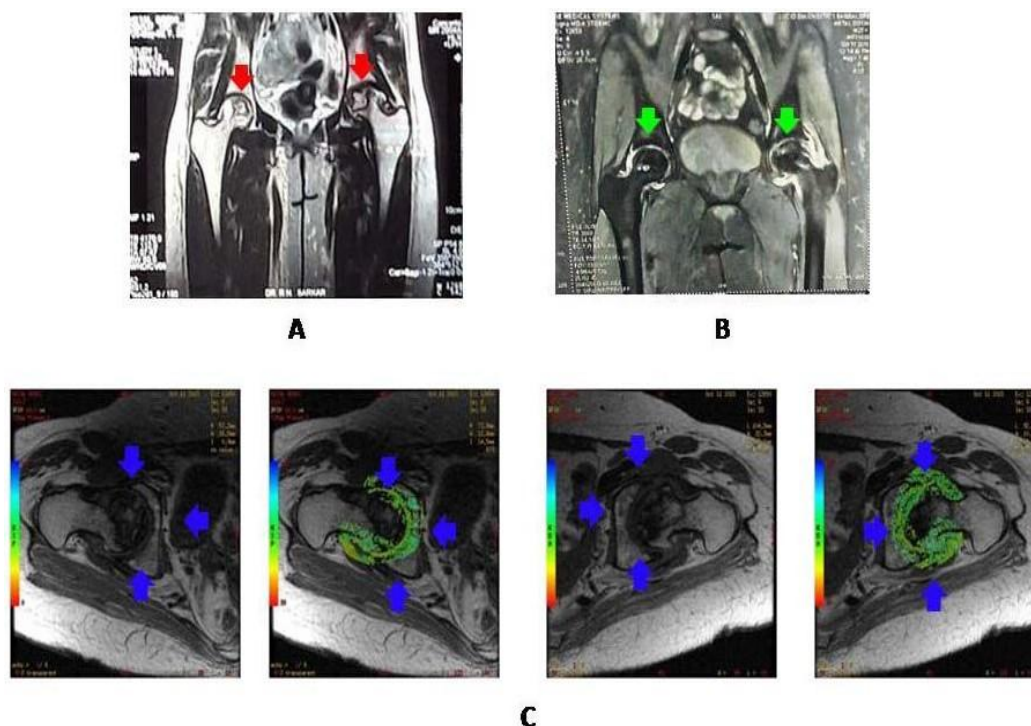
Pre and post treatment cartigrams showing improved cartilage thickness for patient case 1: A (Top Left) - Pre-therapy MRI; B (Top Right) - Post-therapy MRI; C (Bottom 4 images) - Post-therapy cartigrams consisting of alternating images of those with no colors for the lack depiction of hydration within the cartilage and those with colors of cartilage depiction of hydration. Red arrows indicate the location of loss of cartilage and Green arrows show the location of the regeneration of cartilage, respectively, in the pre- and post-therapy MRIs; blue arrows show the cartilage location in the cartigrams
